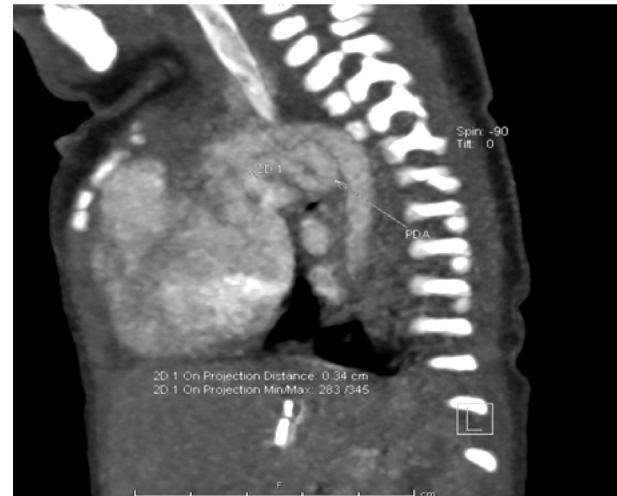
CTA: By using workstation (Siemens Syngo CT), the saggittal view is showing the end point measurement of end pulmonary PDA
